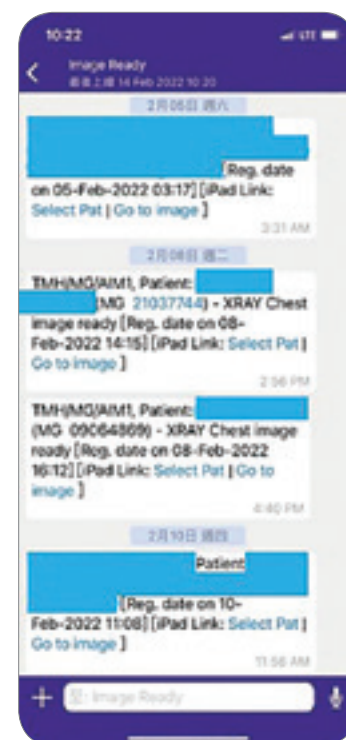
Image Notification for Plain X-ray and e-Request for Reporting
